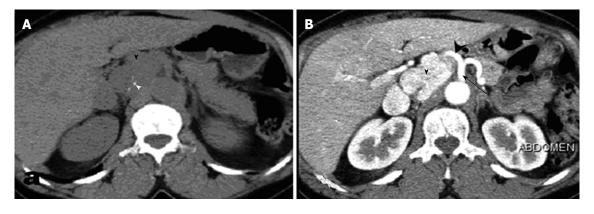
Abdominal computed tomography without (A) and after (B) contrast material administration, showing the tumor (arrowhead) with calcifications (white arrowhead) and precocious enhancement. Note the close tumoral relationship to the celiac trunk (black arrow) and hepatic artery (black arrowhead).
